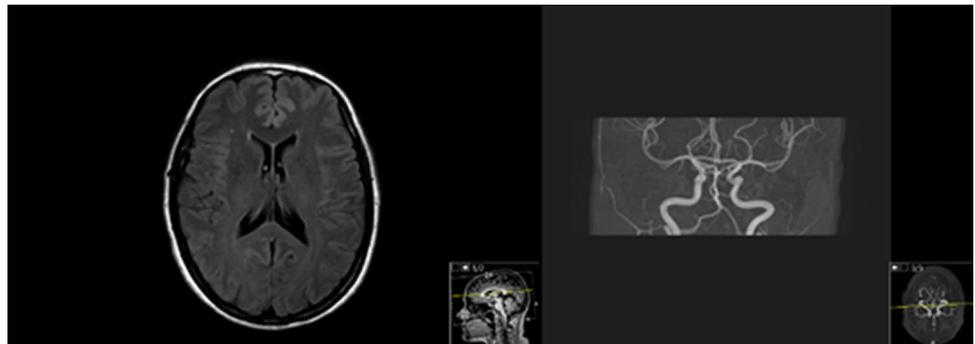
On the left, a T2/FLAIR sequence image of the brain MRI, which was normal. On the right, MRA with no evidence of vasospasm. The patient was asymptomatic, under nimodipine treatment, when this MRI scan was performed
